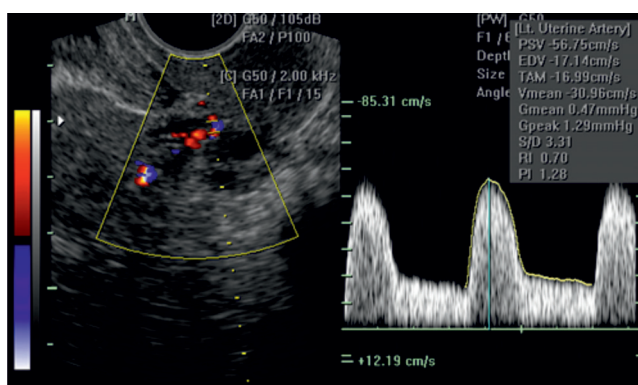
Spectral Doppler in Fertile Female
